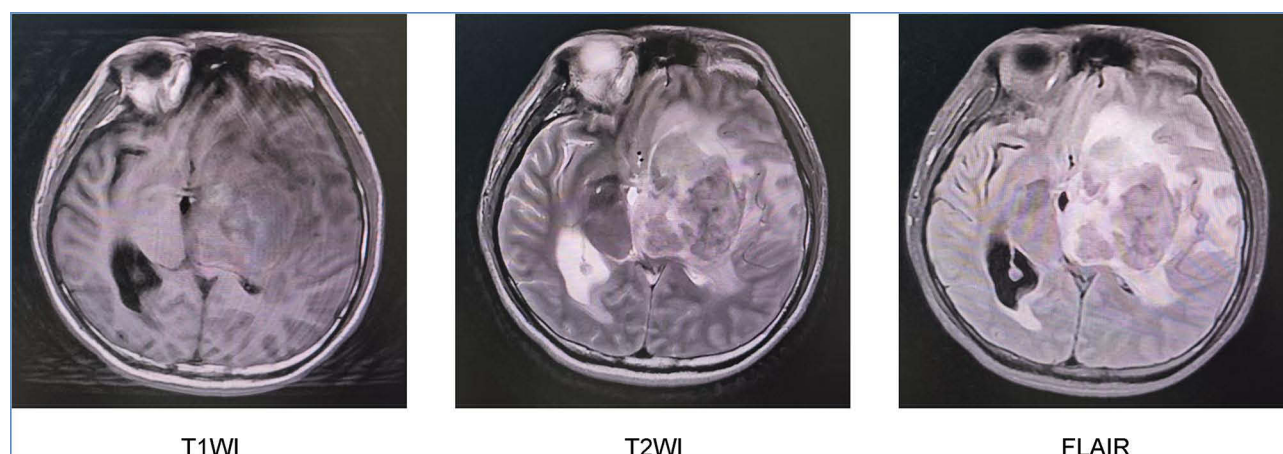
T1WI, T2WI and FLAIR axial views of the patient's cranial MRI on March 31, 2025.
